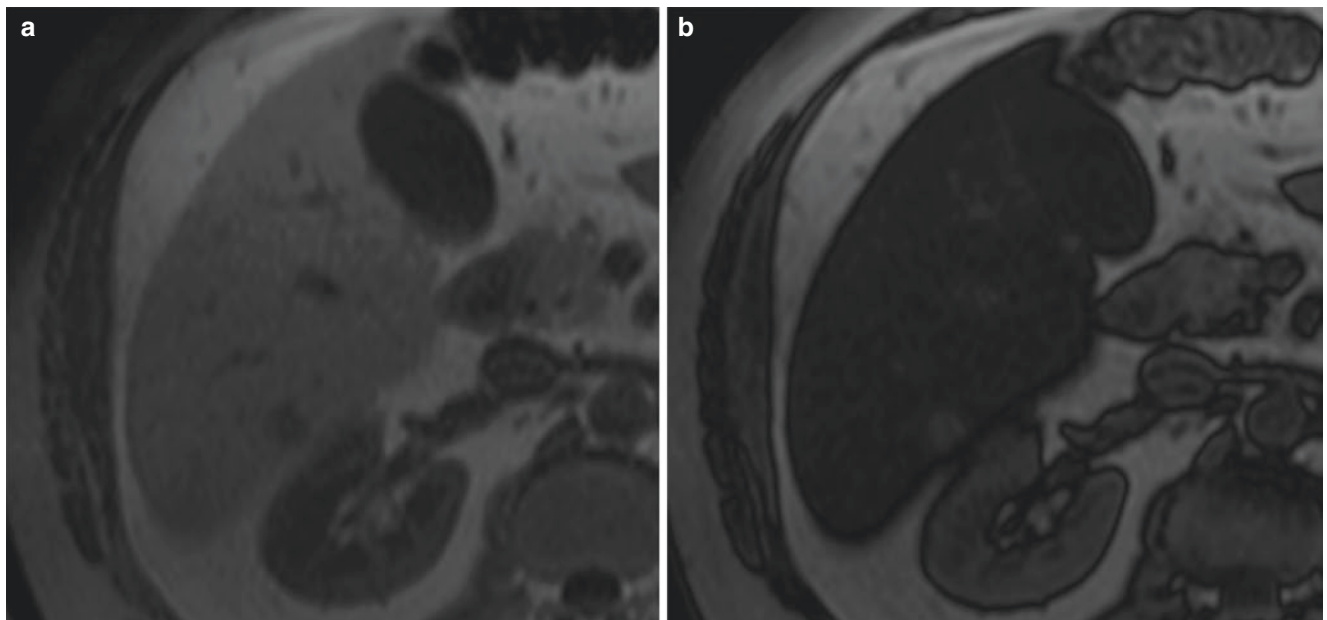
Hemosiderosis. Focal fatty sparing. 59-year-old male with right upper quadrant pain and elevated liver function tests. Axial chemical shift MRI images show signal drop of the entire steatotic liver from in- (a) to out-of-phase (b) with focal fatty sparing in liver segment 6
